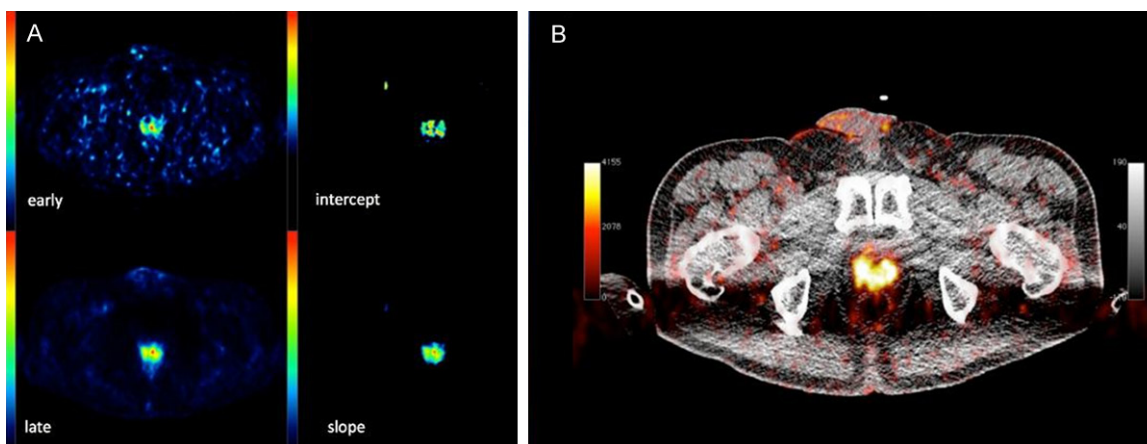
⁶⁸Ga-PSMA-11 PET/CT of a 67-year-old patient with biochemical recurrence of PC (PSA at 6.77 ng/ml) attributed to local recurrence. A. Shows increased ⁶⁸Ga-PSMA-11 accumulation in the prostate fossa in the early dynamic image 7 min p.i. (upper left image, 'early'), which corresponds to the lesion depicted with increased tracer uptake in the late static image 60 min p.i. (lower left image, 'late'). High signal in the area of the local recurrence both in the intercept (upper right image, 'intercept') and the slope (lower right image, 'slope') parametric Patlak-based images. B. Exhibits the PC local recurrence seen as a pathological ⁶⁸Ga-PSMA-11 accumulation in the fused PET/CT image at 60 min p.i.
